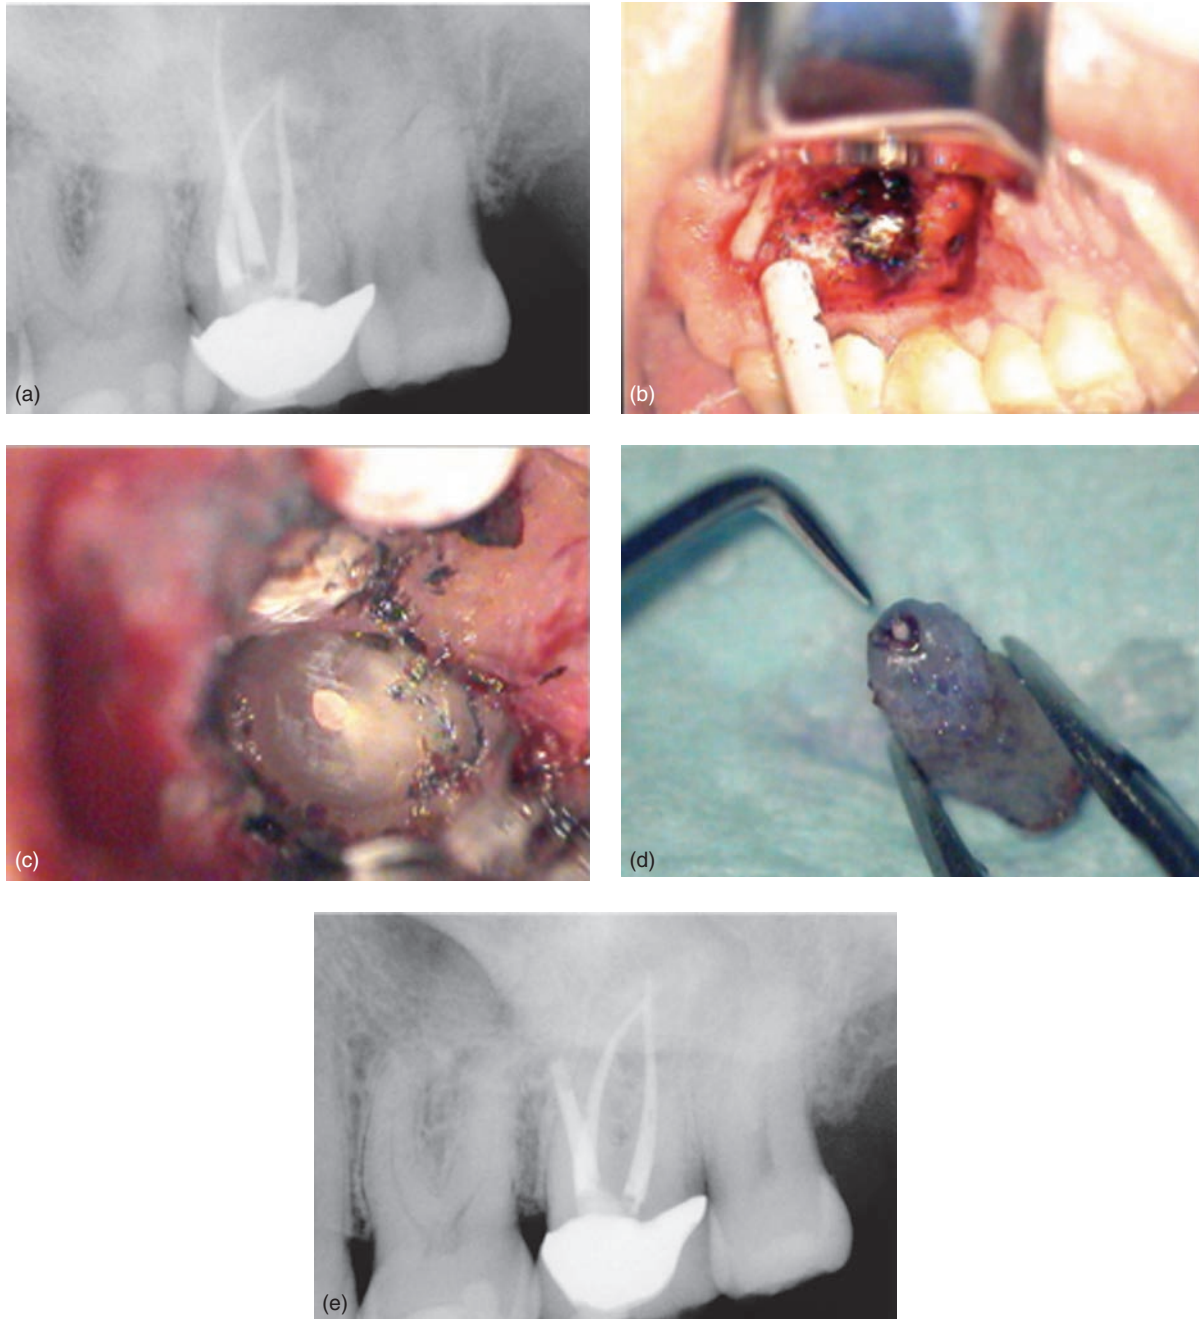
Failed endodontic retreatment of maxillary left second molar. Surgical intervention treatment planned. (a) Preop radiograph. (b) Palatal access. (c) View of resected apex with methylene blue dye in a micromirror. (d) Resected root tip. (e) Postop radiograph.
